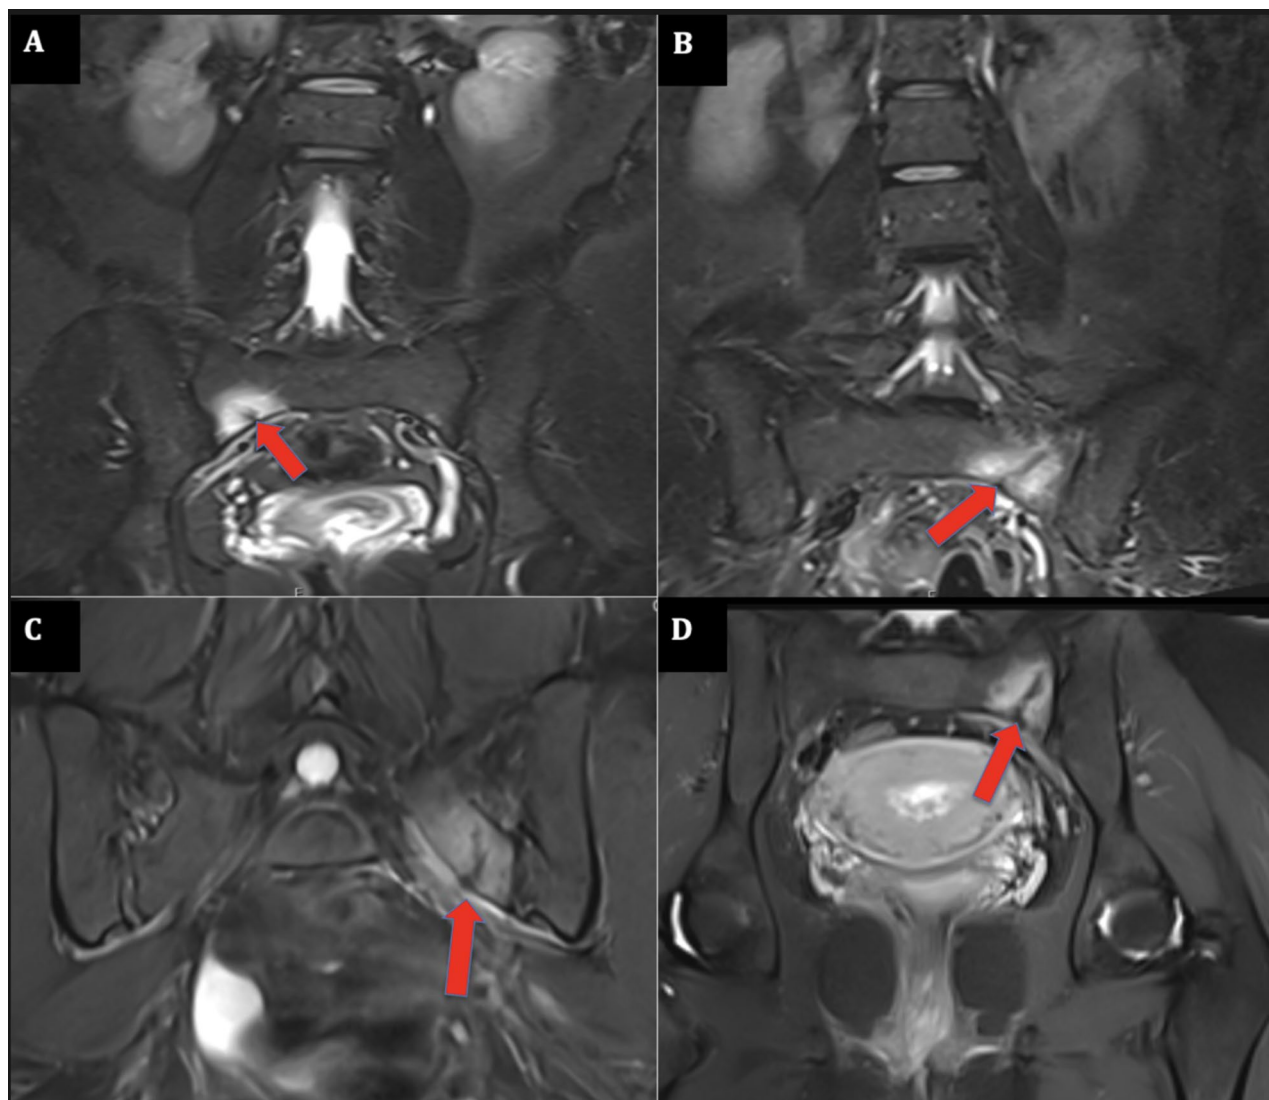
Representative coronal fat-suppressed T2-weighted MRI images demonstrating sacral stress/insufficiency fractures. A Right sacral ala fracture with a hypointense fracture line extending from the inferior cortex, accompanied by surrounding marrow edema. B Vertical hypointense fracture line in the left inferolateral sacrum with extensive adjacent bone marrow edema. C Hypointense fracture line extending superiorly from the inferior aspect of the left inferolateral sacrum, associated with surrounding medullary marrow edema. D Irregular low-signal fracture line in the left inferolateral sacrum extending cranially from the inferior cortical surface, with extensive surrounding marrow edema. Arrows indicate the fracture line
